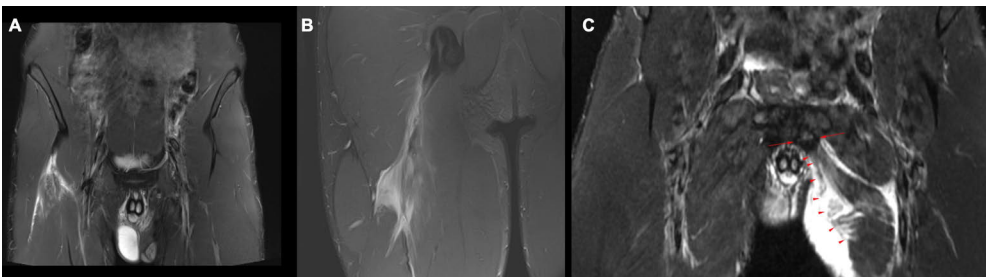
Examples of MRI findings in thigh muscle-tendon injuries. A) Complete rupture of the right RF direct tendon, B) total tear of the proximal BF free tendon, and C) complete rupture of the left proximal adductor longus tendon. MR images by Lasse Lempainen (A–B) and Arnaldo Abrantes (C). Modified from Original Publications I, II, and III.
